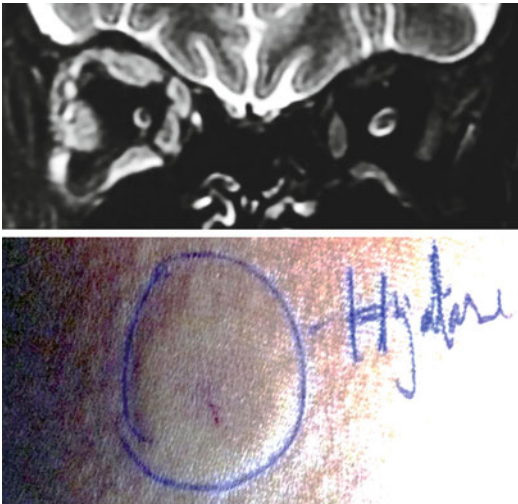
(a) T1 fat-suppressed contrast MRI orbit showing diffuse swelling of right extraocular muscles and fat enhancement of subject from Fig. 52.6. (b) Positive intradermal test after hyaluronidase injection in the same patient
